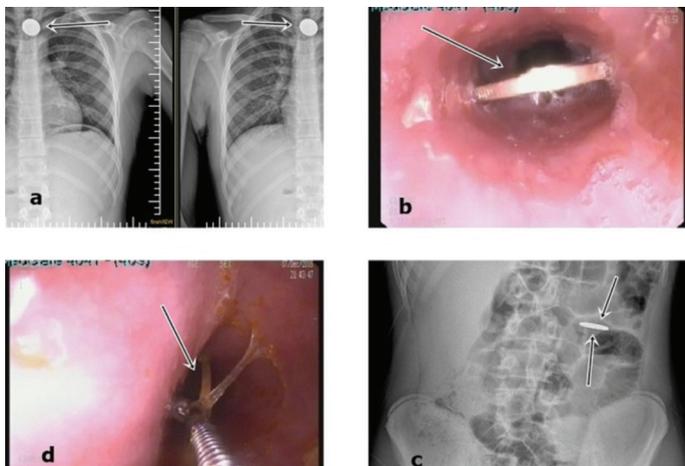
a. A plain radiograph taken at the time of application b. and d) Endoscopic view c. A plain radiograph taken after endoscopy, the coin appears in the small intestine
